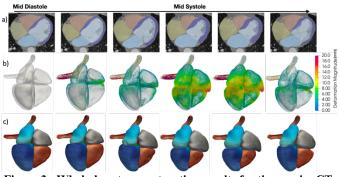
Whole-heart reconstruction results for time-series CT data. A) predicted segmentation b) mesh deformation vectors since late diastole and c) the feature correspondence maps of meshes.
